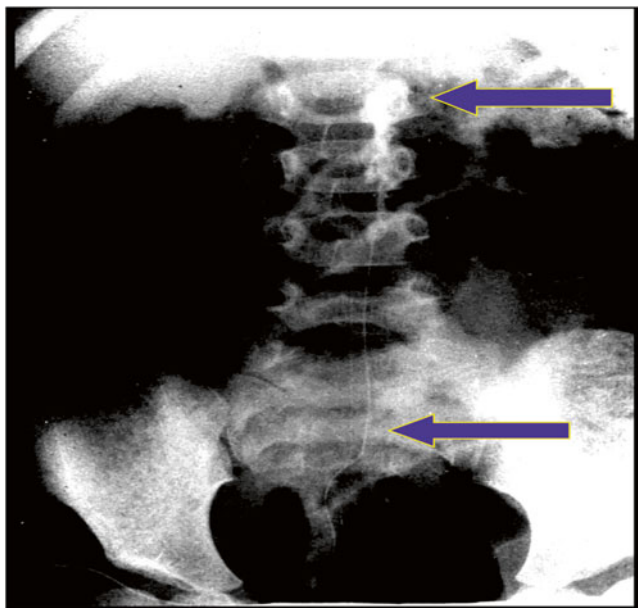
A predetermined length of catheter can be introduced into the epidural space to the desired level via the sacral hiatus. An epidurogram or ultrasound can be used to confirm placement. In this epidurogram, contrast filled the caudal catheter, which was introduced at the sacral hiatus (*lower arrow*), and threaded up to the L1 level (*upper arrow*)
